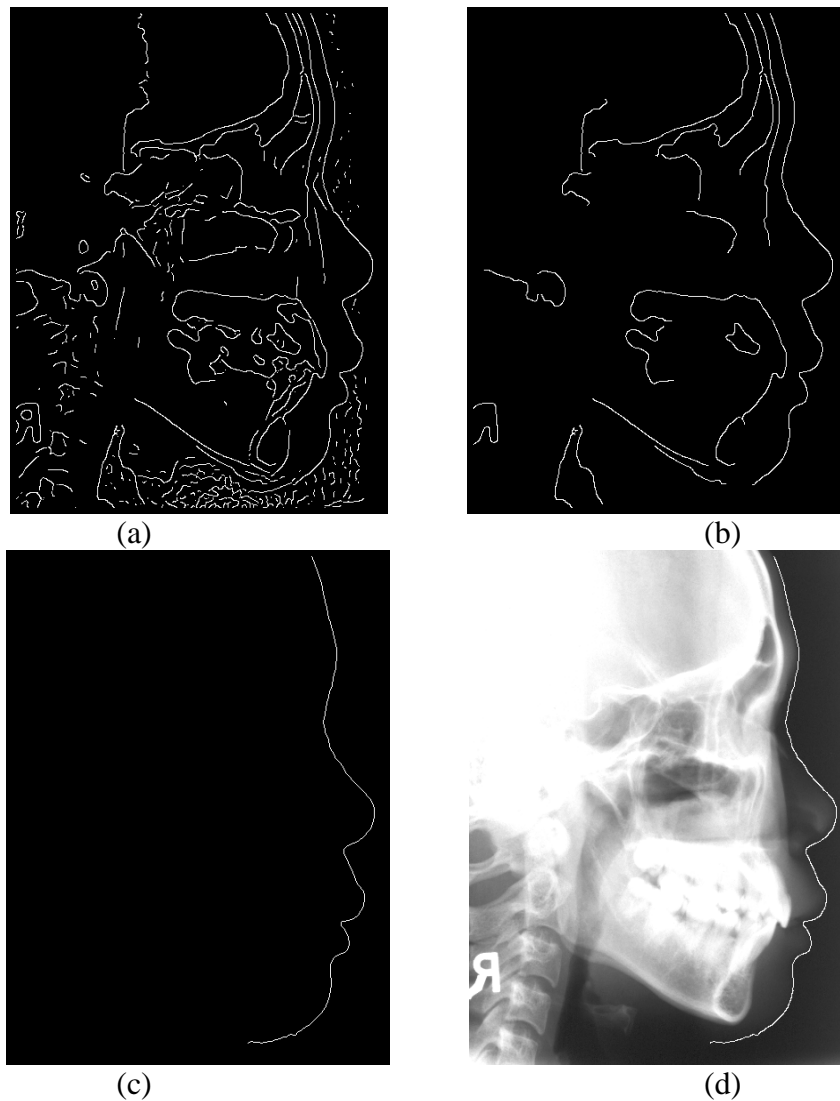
Facial profile extraction. (a) Apply image thresholding, (b) Remove small objects, (c) Trace facial profile, and (d) Superimpose the facial profile on X-ray.
